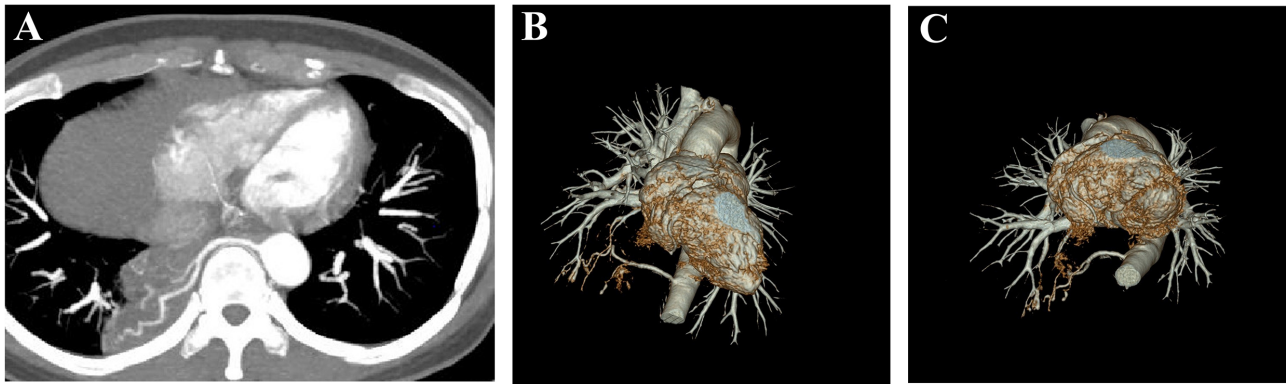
Thoracic aortic CTA and three-dimensional reconstruction demonstrating aberrant systemic arterial supply. (A) Axial computed tomography angiography (CTA) image demonstrating an aberrant systemic artery arising from the thoracic aorta and supplying the lesion in the right lower lobe. (B,C) Three-dimensional CTA reconstruction showing the origin, course, and spatial relationship of the feeding vessel, supporting the diagnosis of intralobar pulmonary sequestration.
